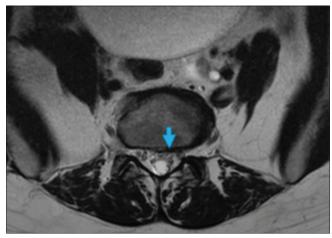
Sagittal T2-weighted imaging of the second round of magnetic resonance imaging showed complete regression of the herniated disc (blue arrow). MRI: Magnetic resonance imaging, T2WI: T2-weighted imaging
